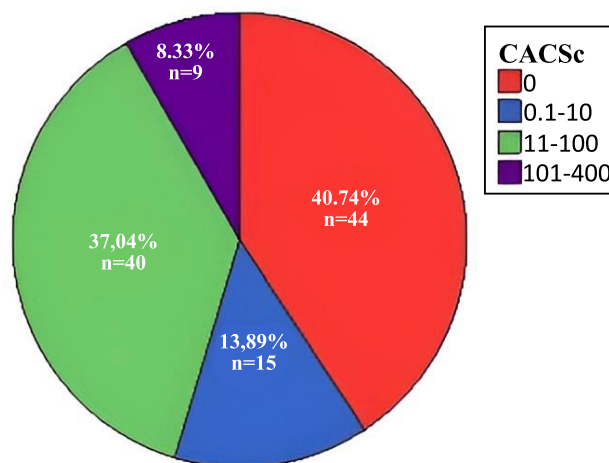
Coronary CT angiography calcium score distribution according to Agatston classification of all patients included in the study.
